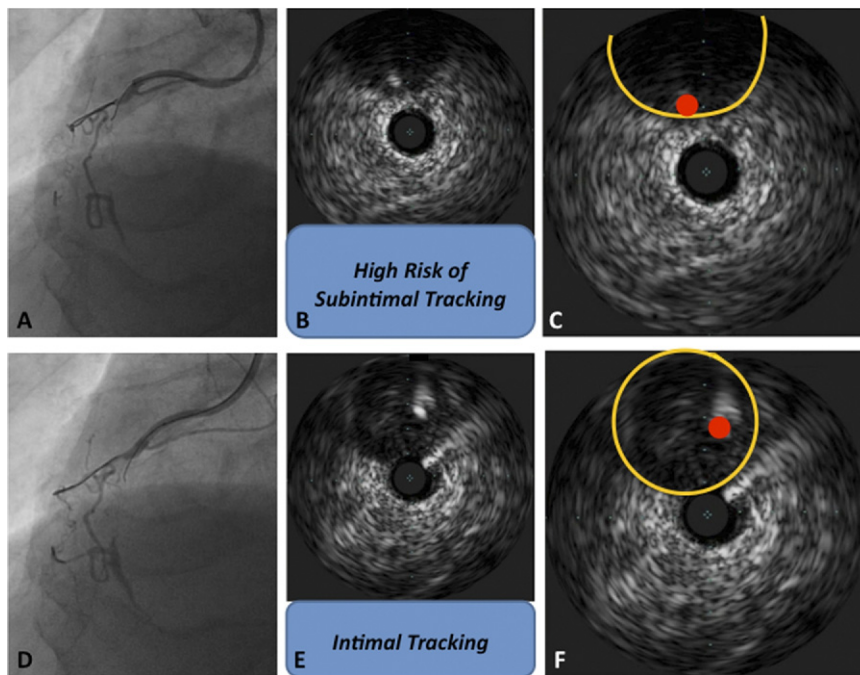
Intravascular Ultrasound Images of the Entry Point in Proximal-Mid Right Coronary Artery Chronic Total Occlusion
